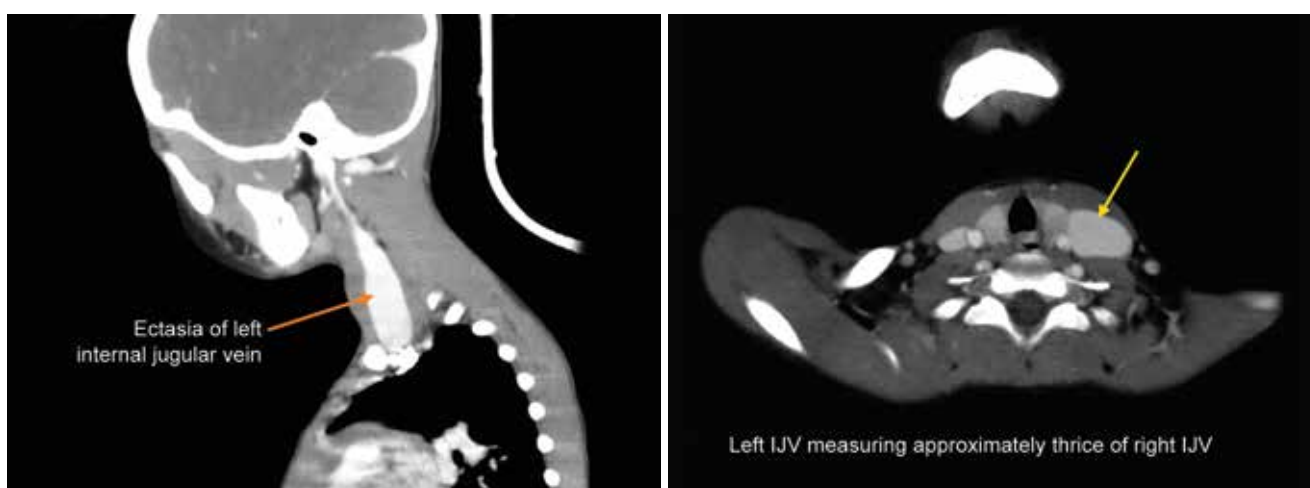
Contrast enhanced CT scan showing left IJV was thrice of right IJV asymmetry of left IJV
